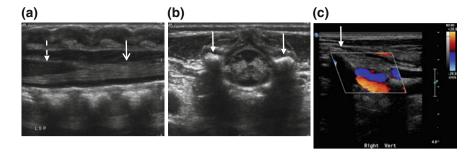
Ultrasound images. Ultrasound images of the spine. Sagittal a and axial b image of the lower spine showing the bone (*solid arrows*), spinal canal, caudal aspect of the spinal cord (*dashed arrow*), and the cauda equina nerve roots (*open arrow*), and c Doppler ultrasound longitudinal image at the level of the cervical spine showing the vertebral bony spinal elements (*shadowing*) and color indicating flow in the vertebral artery
